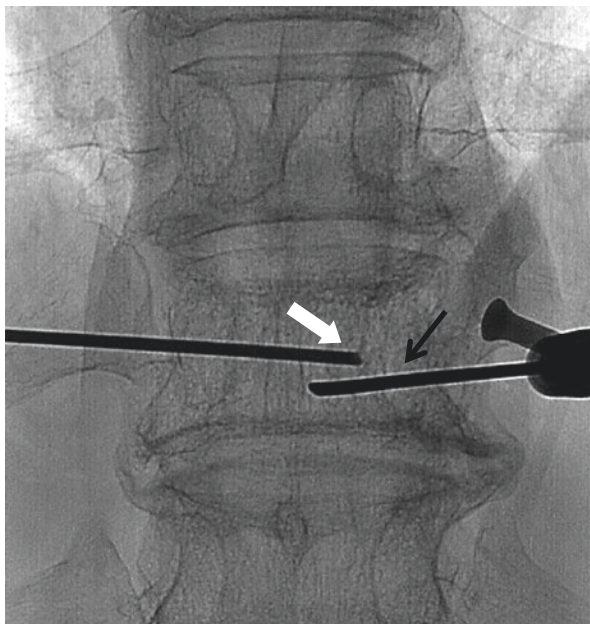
Aggressive vertebral hemangioma in D10, same patient of Fig. 8.13, lateral radiograph: the trocar tip for the VPL (white arrow) is very distal, 1/3 of the anterior of the vertebral body, while the supporting trocar (black arrow) for the microcatheter is quite posterior, adjacent to the vertebral wall
